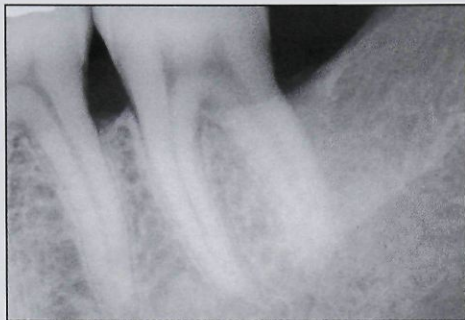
Six-year postoperative radiograph of the area shown in the preoperative radiograph (Fig 1b), indicating a favorable long-term result has been achieved.
